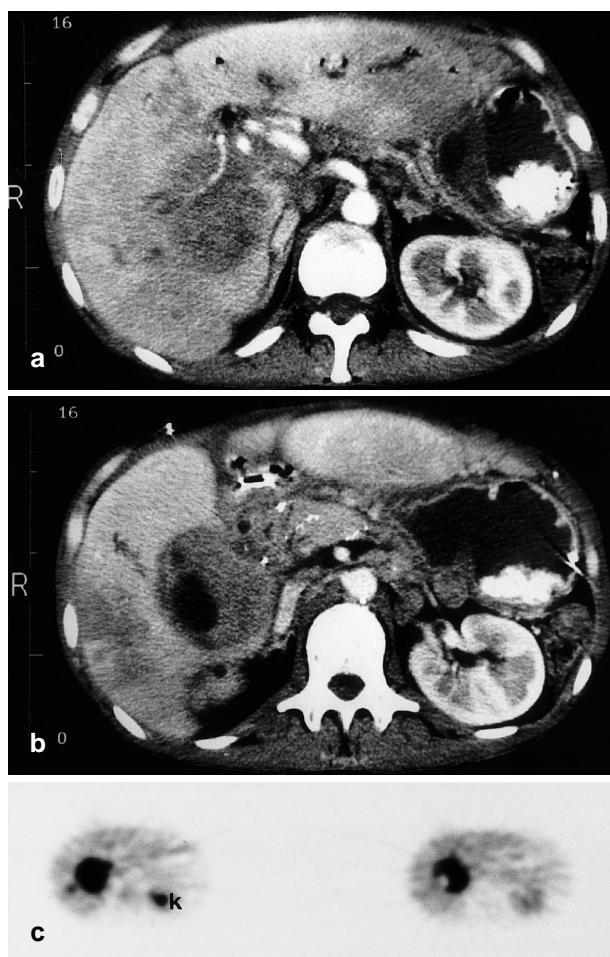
Phlegmonous mass. Patient had a history of chronic pancreatitis and chronic abdominal pain, and presented with weight loss and abdominal pain but no elevation of serum amylase or lipase. a,b Contrast-enhanced CT images of patient with a large mass extending from the pancreatic head into the porta hepatis region. c FDG PET at corresponding transaxial levels shows intense FDG accumulation in the mass (SUV = 11.2). *k* denotes renal urinary tracer
